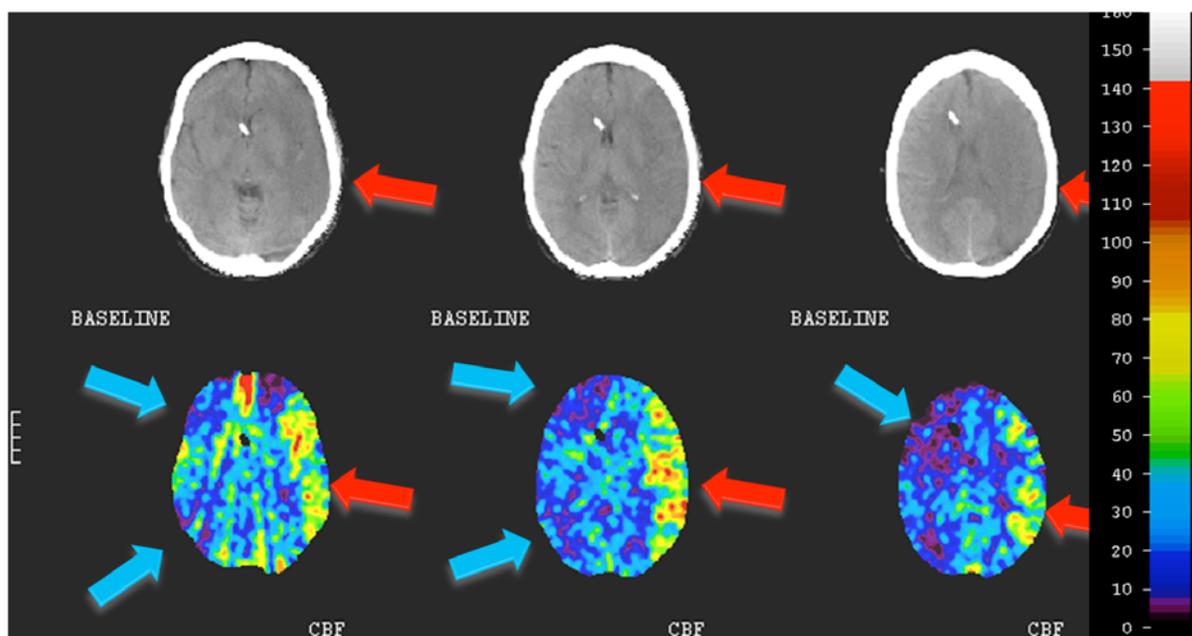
Three level xenon/CT CBF study from case 1. The baseline standard CT levels are in the top row and the corresponding CBF maps are below. The scale on the right is a quantitative scale where each color corresponds to that CBF value in cc/100g/min. The red arrows point to the territory with stroke and hyperemia while the blue arrows point out the tissue becoming ischemic (CBF < 20cc/100g/min) with hyperventilation.
